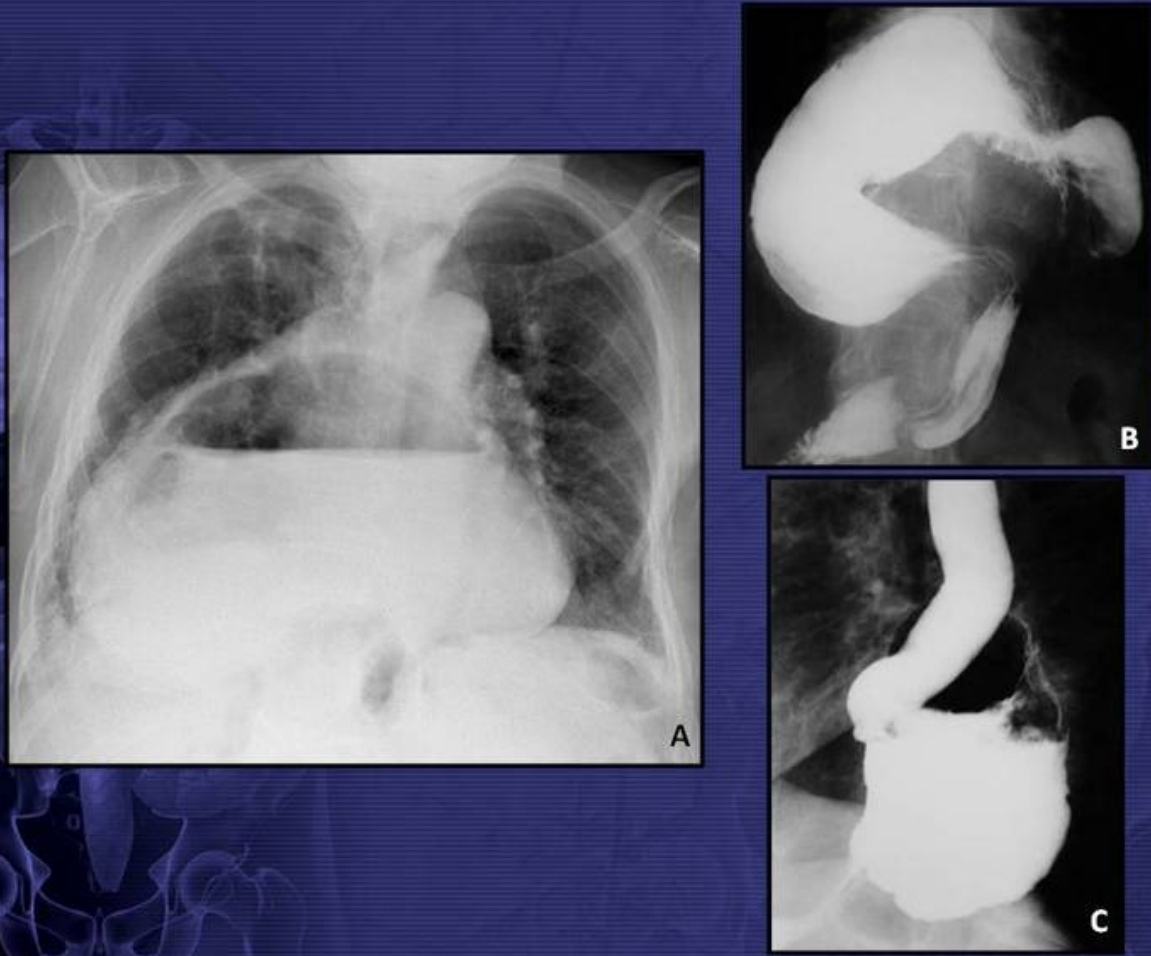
Organo-axial gastric volvulus. (A) Chest frontal radiograph shows a large retrocardiac opacity, consistent with the stomach, with an air-fluid level. (B) and (C) Barium x-rays demonstrate an organo-axial gastric volvulus in a sliding hiatal hernia.
